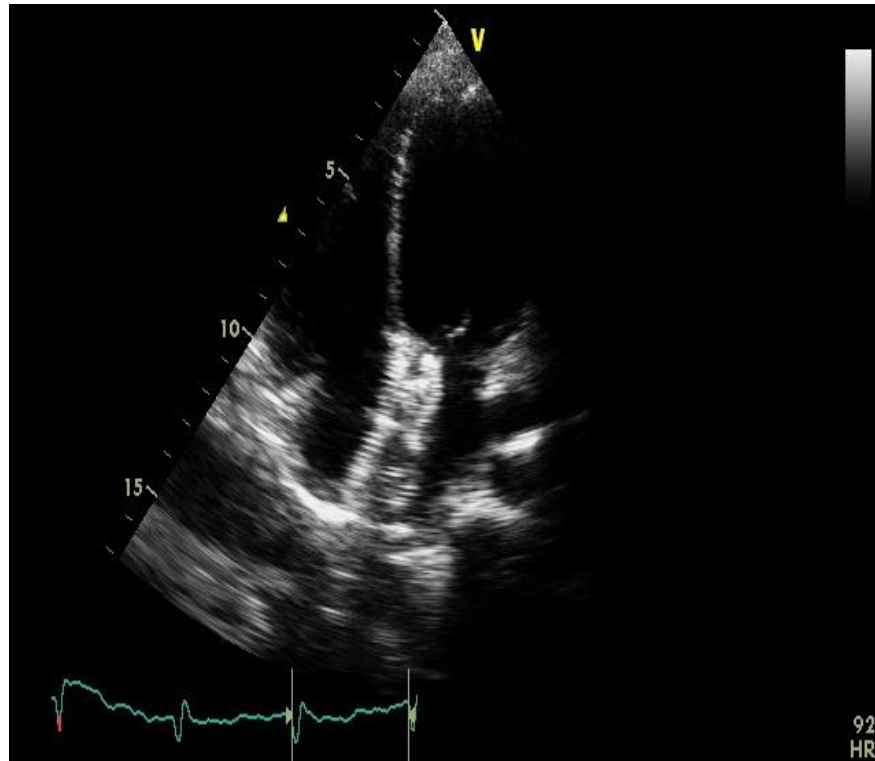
ASD device seen in apical 4 chamber view
